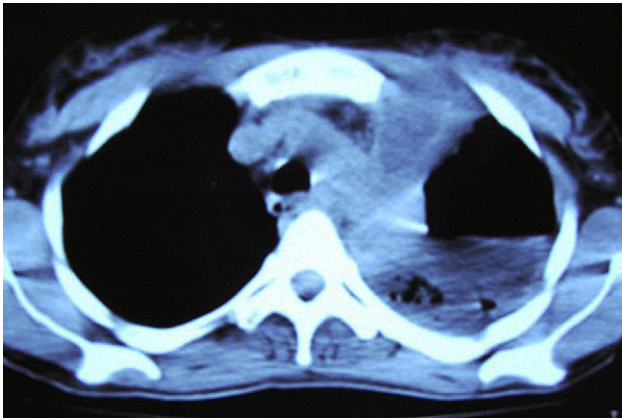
Computed tomography of the chest showing large left pleural effusion and pneumothorax.
